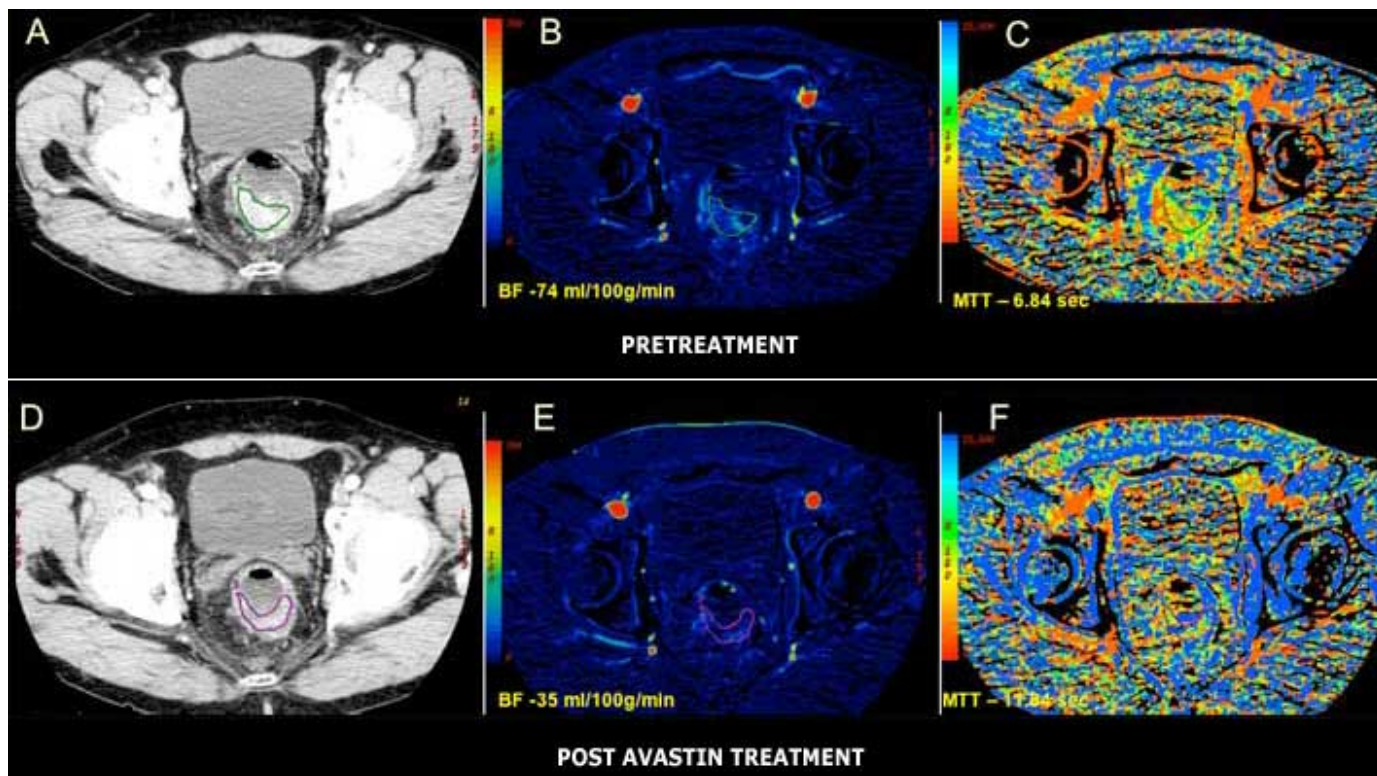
CTP images obtained before and after treatment with anti-angiogenic agent Avastin in a 64 year-old male with rectal cancer. (A) Pre-treatment axial contrast enhanced CT image in the dynamic phase shows the enhancing rectal carcinoma with corresponding colored perfusion maps demonstrating (B) elevated blood flow (74 ml/100 g/min) and (C) reduced MTT (6.84 sec). (D) Post treatment with Avastin axial contrast enhanced CT image shows reduced enhancement with corresponding colored perfusion maps demonstrating (E) reduction in blood flow (35ml/100g/min) and (F) increase in the MTT (11.8 sec).
